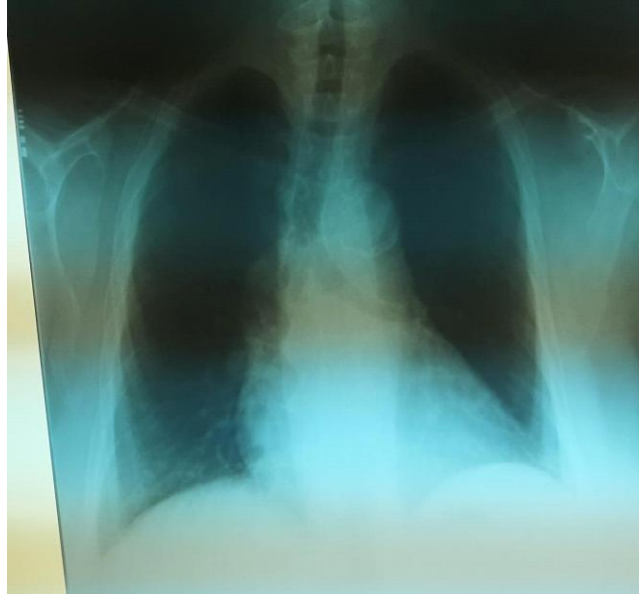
Chest x-ray after being discharged
